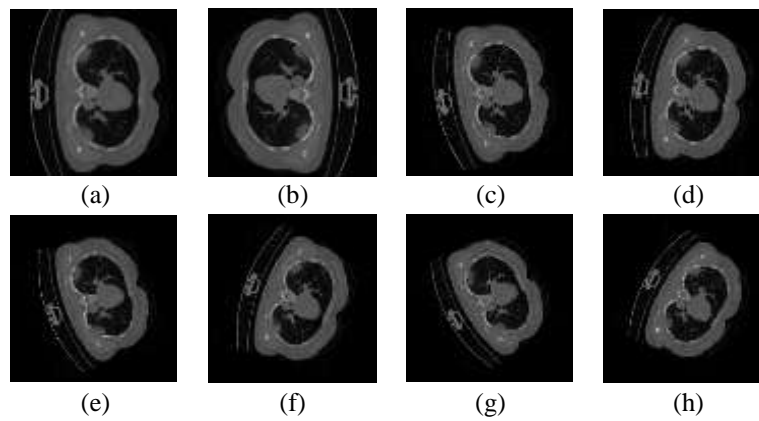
The pre-processed output CT images after augmentation, where: (a) original COVID-19 lung CT image, (b) CT image rotated by angle 180 degree, (c) CT image rotated by angle 10 degree, (d) CT image rotated by angle -10 degree, (e) CT image rotated by angle 20 degree, (f) CT image rotated by angle -20 degree, (g) CT image rotated by angle 30 degree, and (h) CT image rotated by angle -30 degree.
